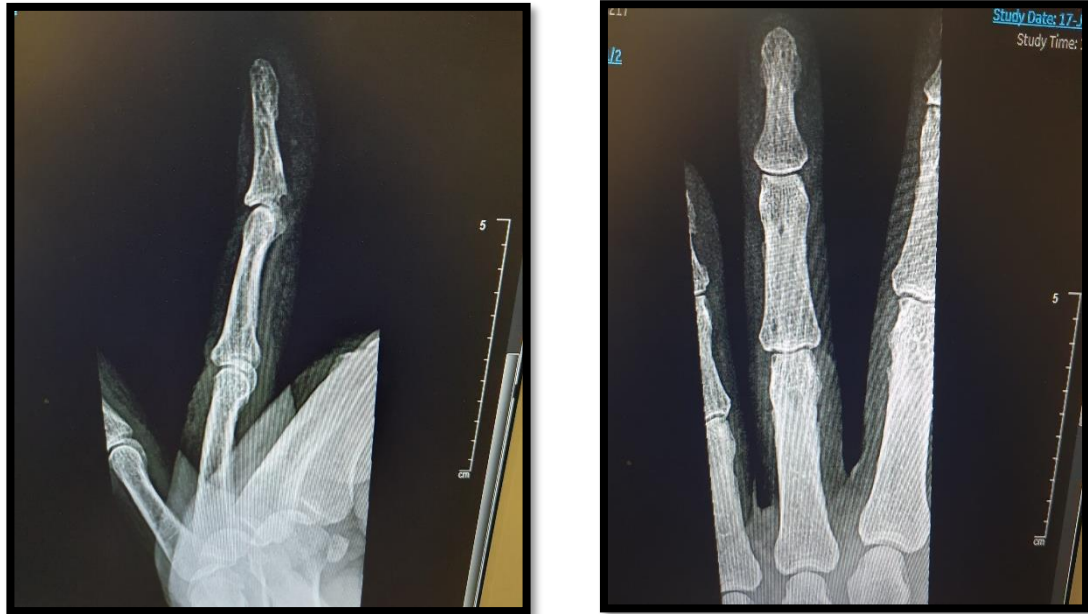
Pre-operative radiographic presentation (X-ray) findings of patient's ring finger
